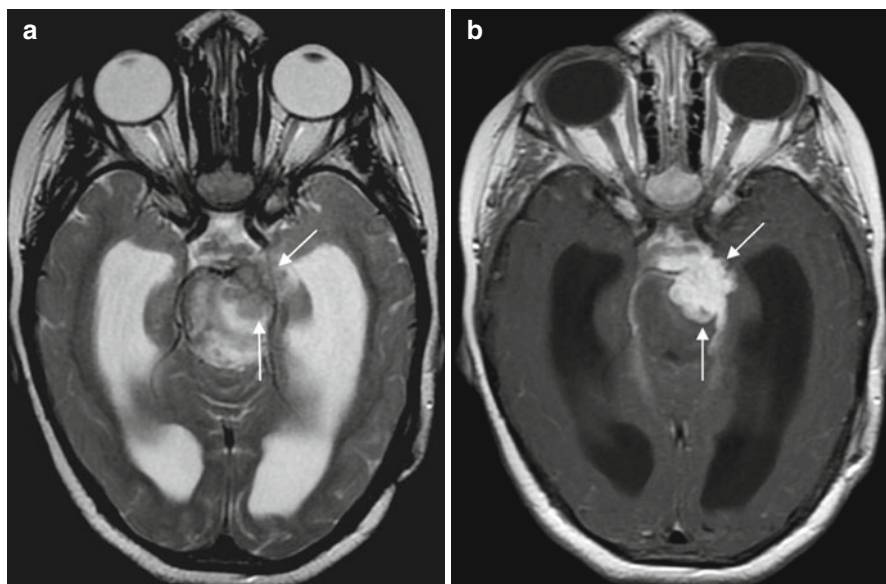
Multiple parenchymal lesions in the left side of the brainstem after treatment for TB meningitis, consistent with tuberculomas. These are (a) hypointense on T2-weighted images (arrows) and (b) avidly enhancing (arrows)
